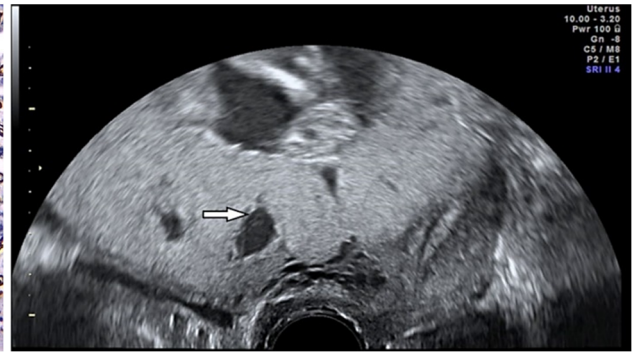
Transvaginal sonogram: placenta lacunae (white arrow) in pregnant woman, 33 years old, 35 GW, no obstetrical history in the past, present delivery way by Cesarean section, placenta praevia associated with placenta increta. GW: Gestational weeks.
